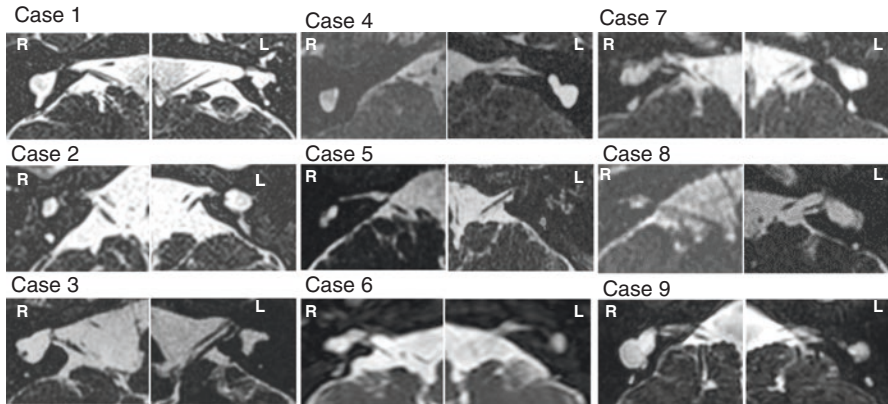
MR imaging of the temporal bones of nine infants with CC deformities and their eighth nerve
